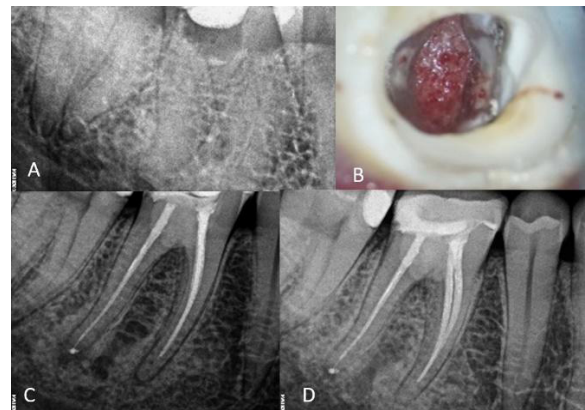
Mandibular right first molar with a large furcal perforation: (A) a preoperative radiograph shows a perforation in the pulp chamber, (B) a clinical view of the perforation, (C) a radiograph of the perforation repair with Biodentine and after root canal therapy, (D) a follow-up radiograph at 1 year. The outcome was classified as healed
